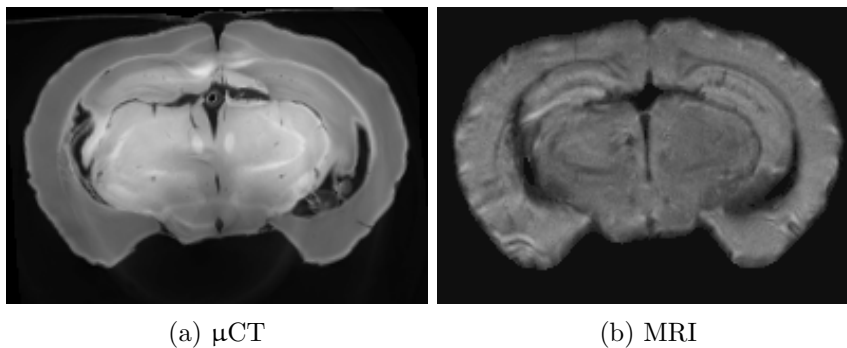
Transformation calculated at native MRI resolution (50 μm).
